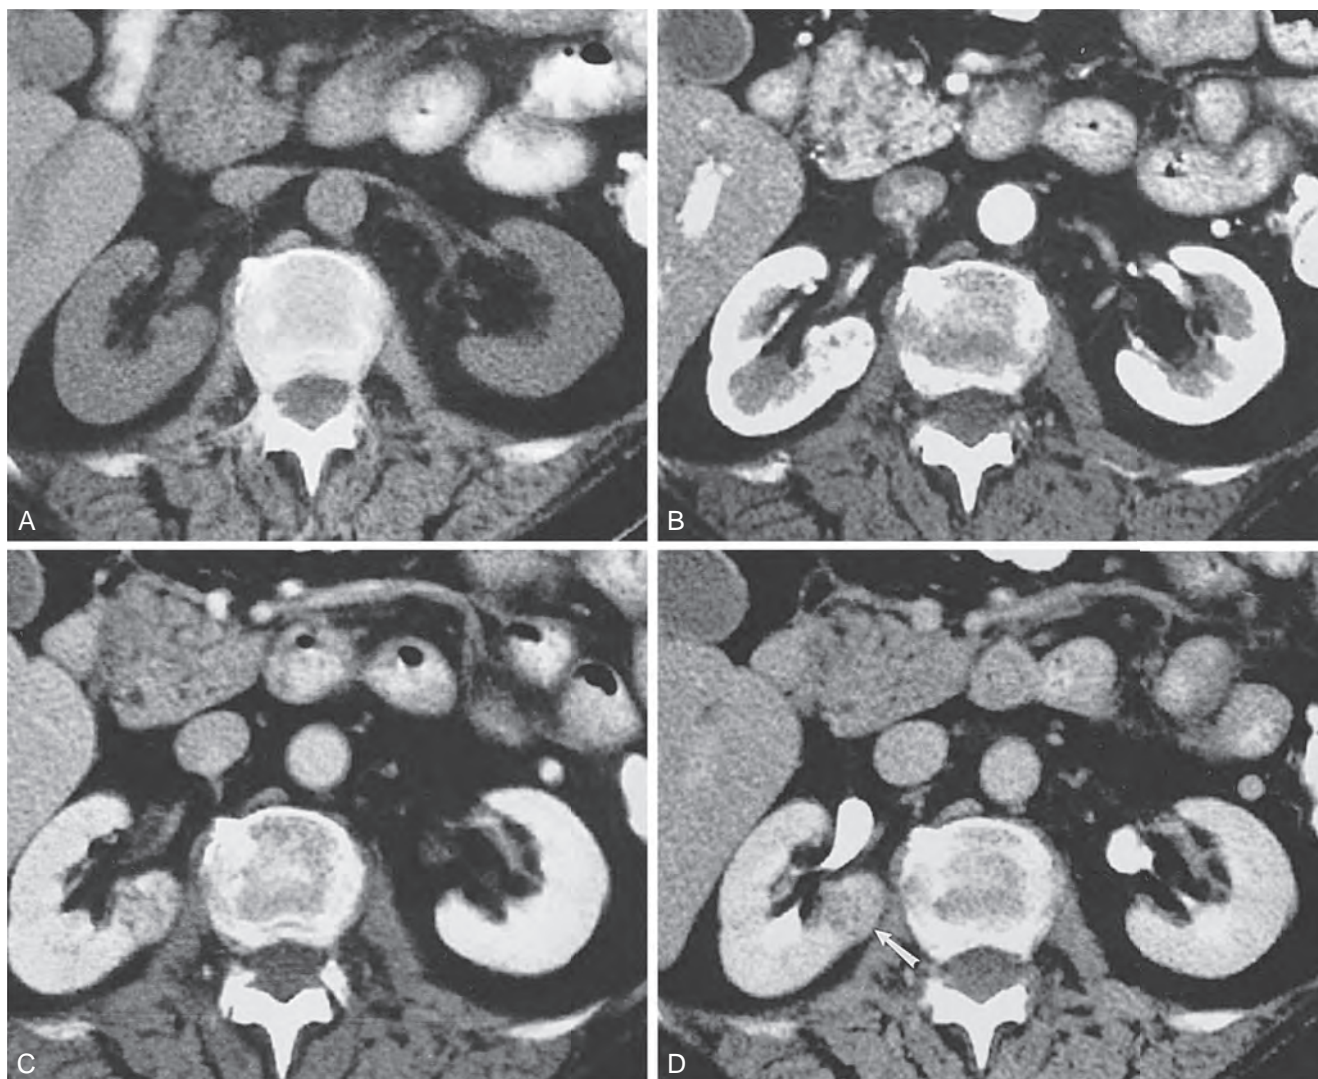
Small renal cell carcinoma in the infrahilar lip of the right kidney is not easily seen on unenhanced image (A). On corticomedullary phase image (B), the lesion is subtly visible as a hyperenhancing focus within the renal medulla. On nephrographic (C) and pyelographic phase (D) images, the full extent of the lesion (arrow) within the medulla and cortex is depicted. (From Brink JA, Siegel CL. *Computed tomography of the upper urinary tract*. In: Pollack HM, McClenan BL, Dyer R, et al, editors. *Clinical urography*. 2nd ed. Philadelphia: Saunders; 2000.)
